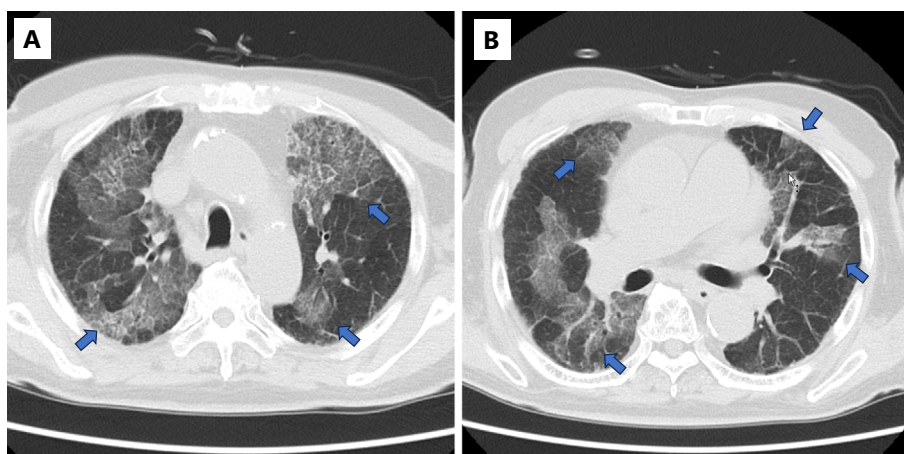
Axial CT images of the upper (A) and middle (B) lung fields of the Case 1. Multiple non-regional ground-glass opacity was observed in both lungs (arrows).
